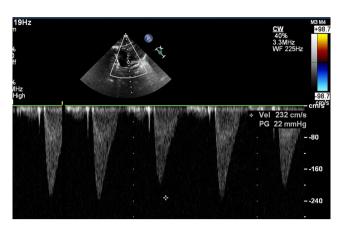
Doppler investigation showing peak systolic gradients of 32 mmHg across the narrowed segment of RPA.
